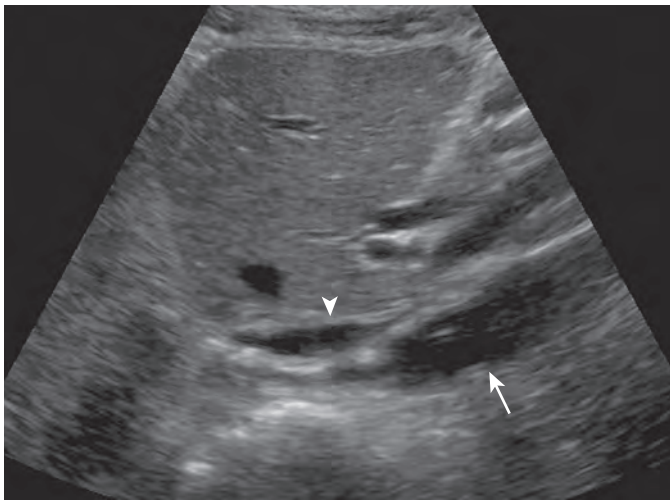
Piggyback IVC anastomosis. Sagittal ultrasound image shows ligated donor infrahepatic IVC (arrowhead) and recipient IVC (arrow).
